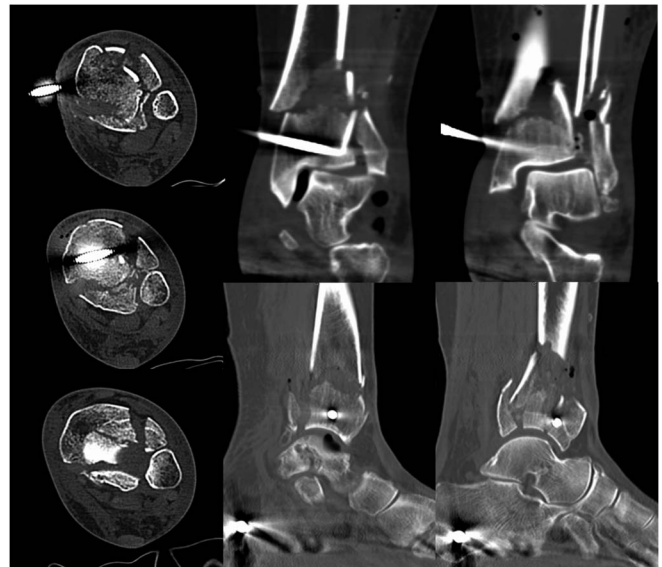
Axial, sagittal, and coronal computed tomography images of the left pilon fracture after provisional stabilization.
